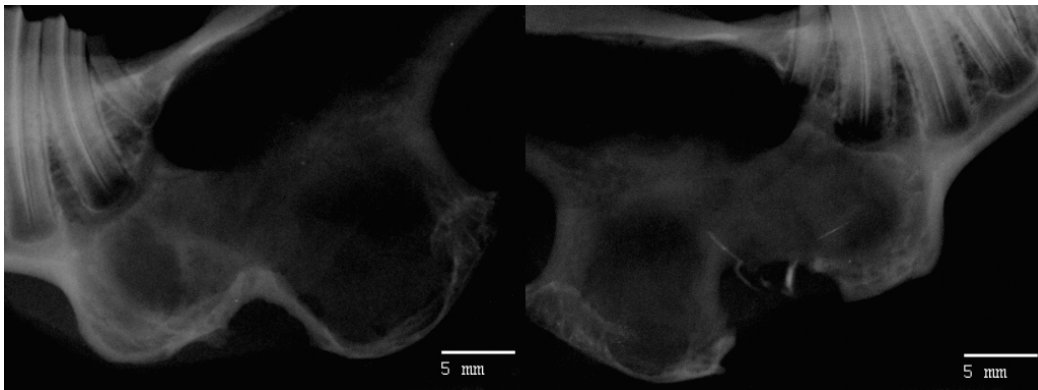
Radiographs of the controls after 52 weeks of healing. The mandible on the left side was neither covered with membrane nor filled with BAG. On the right side a BAG-treated mandible is shown. The edges of the defects are rounded in both cases, and the ossification is not complete (Asikainen et al. 2006a). (With the kind permission of J Royal Society Interface)*
